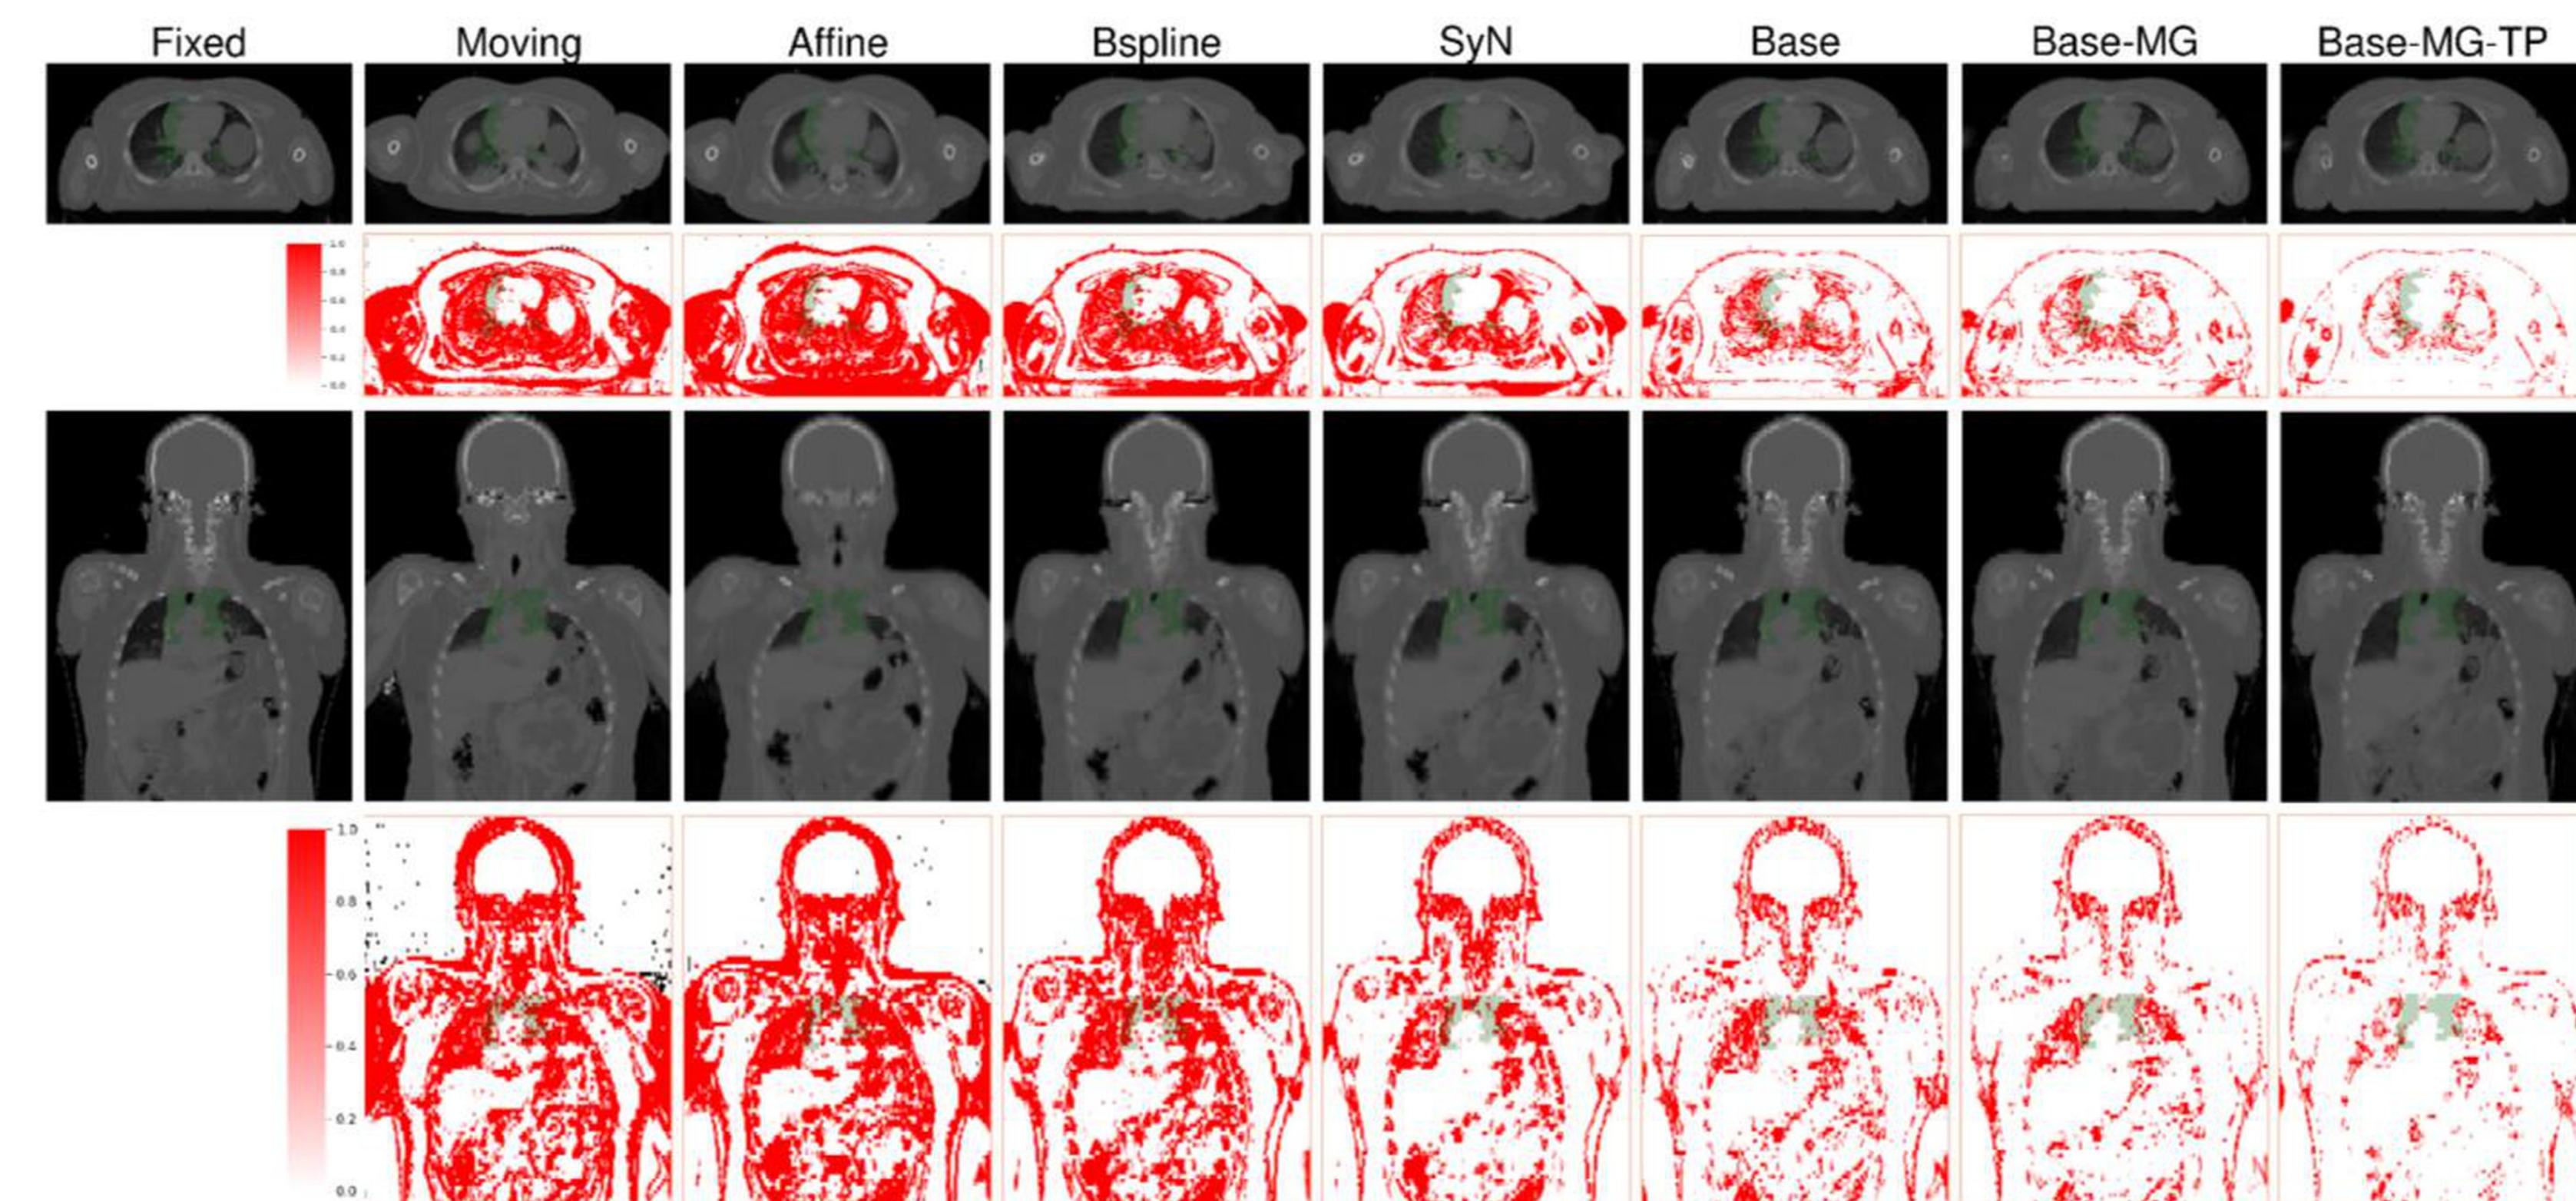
Qualitative comparison of warped CT and difference maps (CTV in green).
